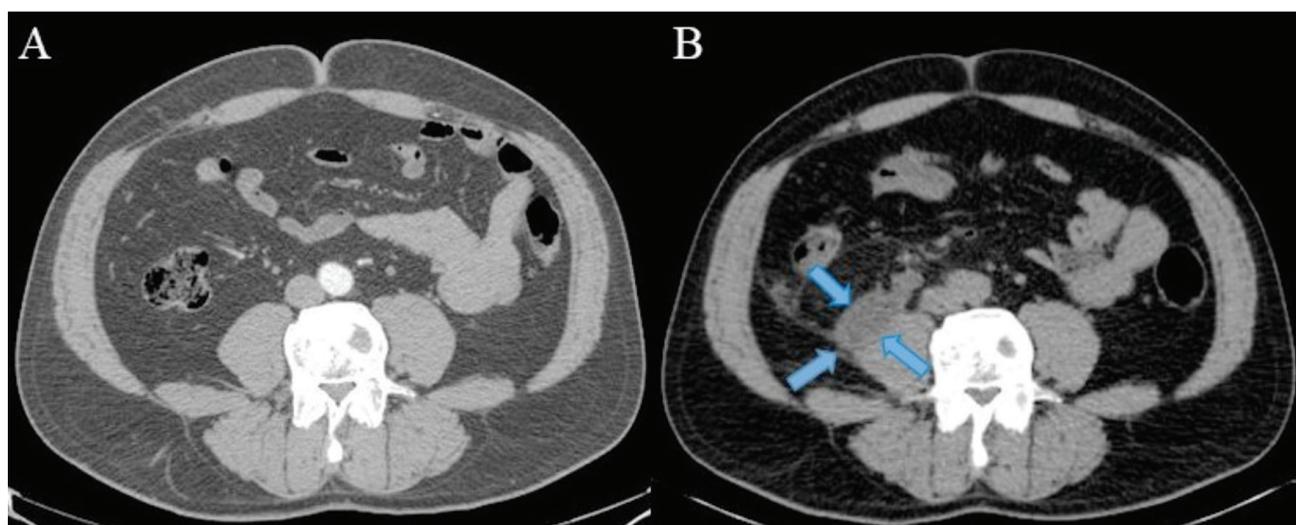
Contrast enhanced CT image before the biopsy (A) and CT image of PET/CT after the biopsy (B). Urinoma was shown (B blue arrows) on the right iliopsoas muscle. CT scanning results of the patient before and after the biopsy procedure were compared and it was recognized that the lesion associated with the right ureter, emerging following the biopsy procedure was a lesion in fluid density consistent with urinoma. Urinomas may be asymptomatic and occult initially, but may lead to abscess formation and electrolyte imbalances if not diagnosed and managed appropriately (1). Ureteral leaks can result from trauma, ureteral obstruction, tumors or endourologic interventional procedures (2,3,4). The second most common complication of abdominal laparoscopic surgery is ureteral injury (5). Urinomas are rare complications of ureteroscopy. The diagnosis is usually made by ultrasound or CT (2). The incidental discovery of a urinoma by ¹⁸F-FDG PET/CT was previously reported (6,7). In our case, urinoma originating from iatrogenic urinary tract injury following endourological biopsy procedure was detected incidentally on PET/CT scan.
